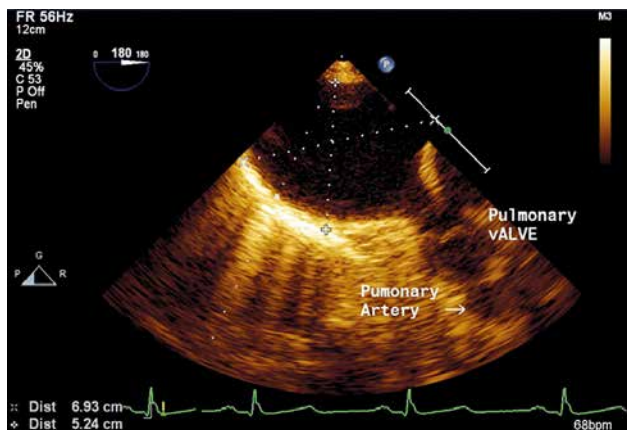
Pre-operative echocardiographic images. Dimensions of the pseudoaneurysm
